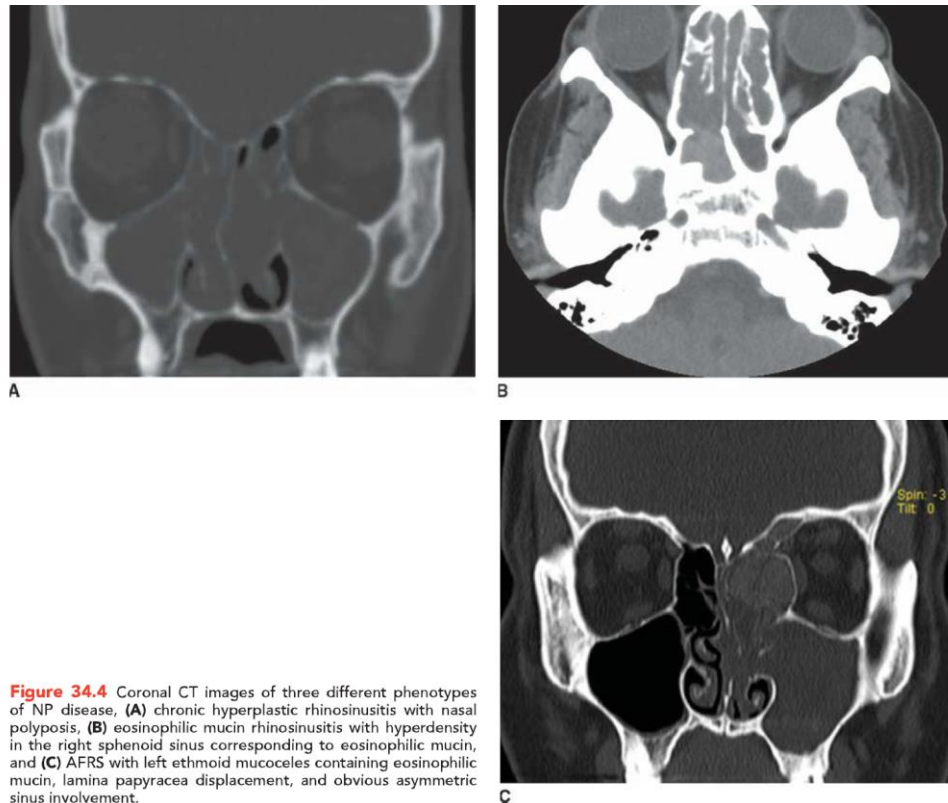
Coronal CT images of three different phenotypes of NP disease, (A) chronic hyperplastic rhinosinusitis with nasal polyposis, (B) eosinophilic mucin rhinosinusitis with hyperdensity in the right sphenoid sinus corresponding to eosinophilic mucin, and (C) AFRS with left ethmoid mucocoeles containing eosinophilic mucin, lamina papyracea displacement, and obvious asymmetric sinus involvement.
